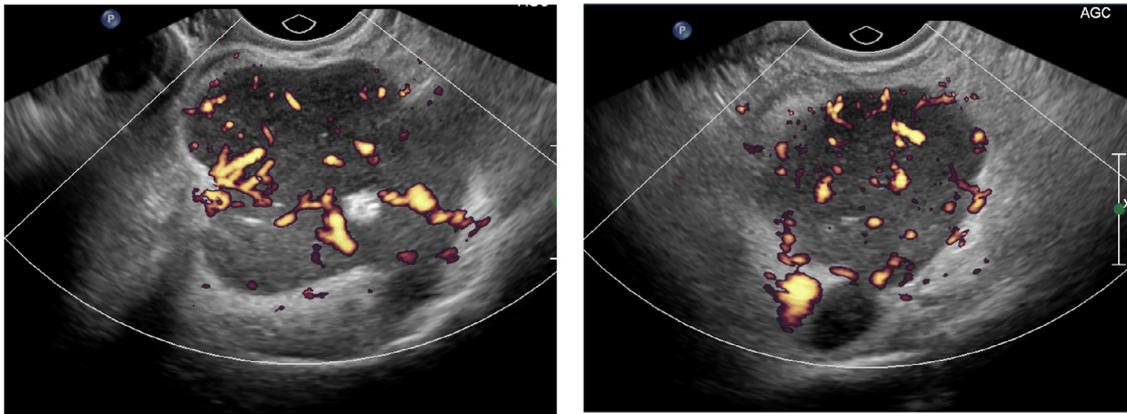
A large solid adnexal mass with marked vascular flow consistent with a color Doppler score of 4.
